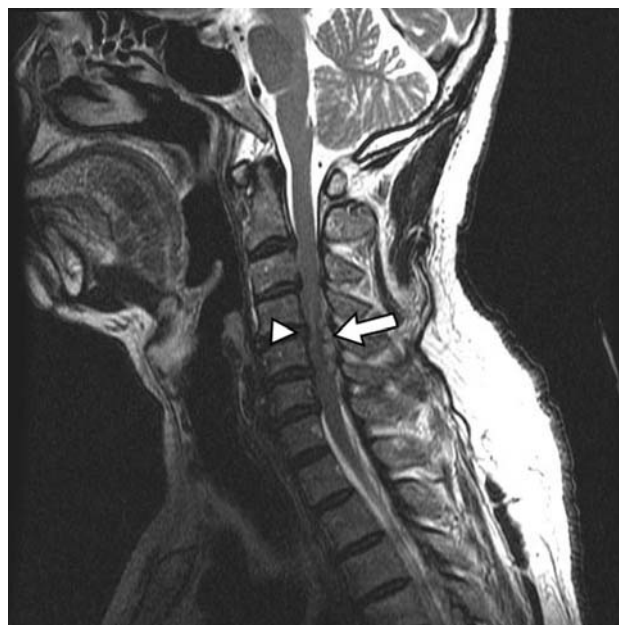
Sagittal T2-weighted cervical magnetic resonance image shows a longitudinal posterior epidural hematoma from C4 to C5 (arrow), compressing the spinal cord (arrowhead)
